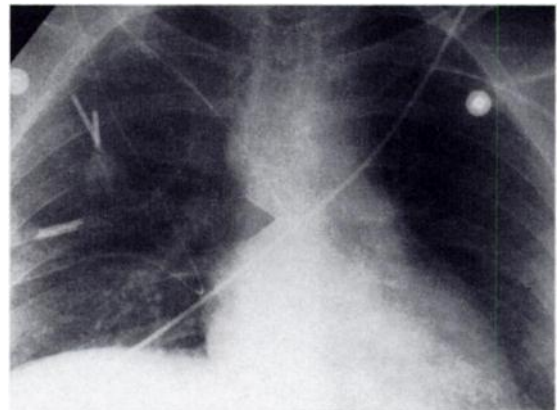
Anteroposterior portable chest radiograph shows location of tip of hyperalimentation catheter (arrow).
